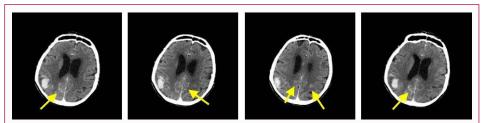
CT of the brain with intravascular contrast injection showing micronodular leptomeningeal enhancement on the right parietal lobe bilaterally.
